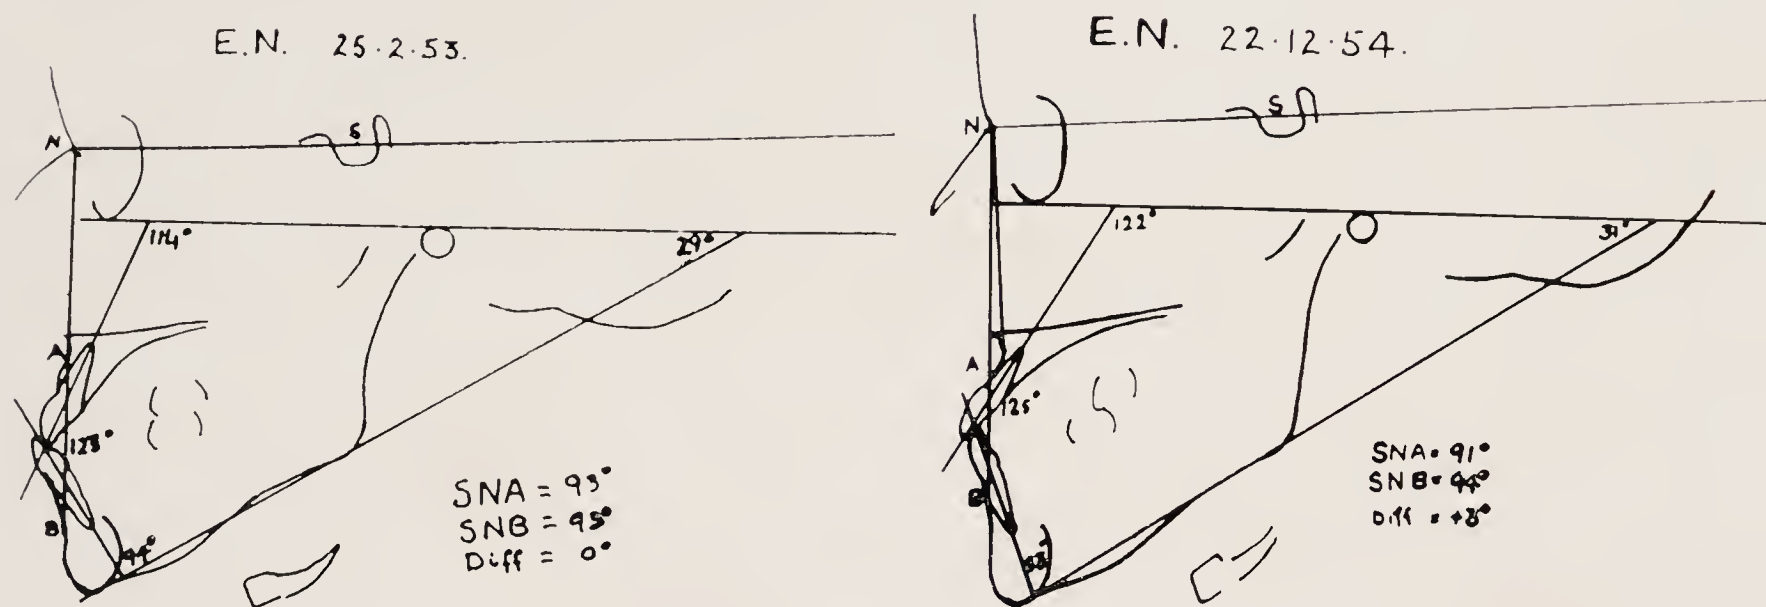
Tracings of lateral skull X-rays of a patient with a Class III (Angle) malocclusion on an intermediate type of skeletal pattern before and after treatment. There was a slight over-closure factor. Considerable tipping of the upper incisors labially and the lower incisors lingually resulted from treatment. $\overline{44}$ were extracted. The incisors remained clinically loose after appliances were removed.
